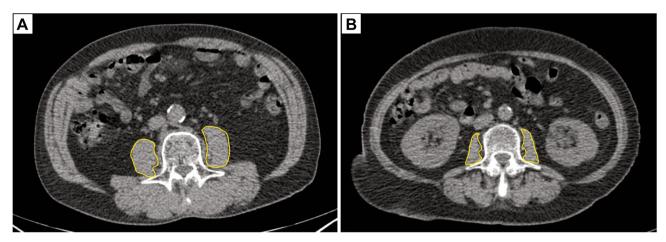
Cross-sectional images from pre-treatment computed tomography (CT) scanning were used to measure the areas of the left and right psoas muscles of the third vertebra. (A) "No sarcopenia" was defined as a total psoas $area/m^2 > 5.0 \text{ cm}^2/m^2$. (B) "Sarcopenia" was defined as a total psoas $area/m^2 \le 5.0 \text{ cm}^2/m^2$.
